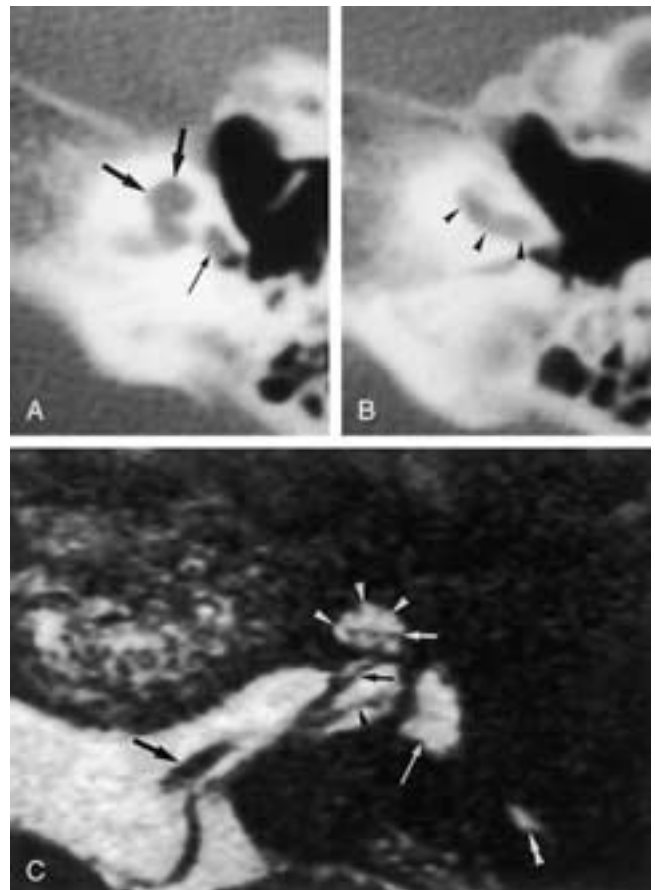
Mondini malformation and hypoplasia of the cochlear branch of the VCN in a patient with the branchio-oto-renal syndrome. A and B, Axial CT image through the apical and second turns of the left cochlea (A) and through the basal turn (B). The apical and second turns of the cochlea cannot be separated from one another on CT (*large black arrows*). The basal turn, however, has a normal shape and appearance (*black arrowheads*). Normal vestibule (*long black arrow*). C, Axial 0.7 mm thick T2-weighted gradient-echo image through the left IAC. An incomplete and obliquely orientated septum (*small white arrow*) is seen between the apical and second turns of the cochlea (*white arrowheads*). The cochlear branch of the VCN (*small black arrow*) is much smaller in diameter than the facial nerve (*large black arrow*). Normally these nerves have a more equal size. Normal vestibule (*long white arrow*), posterior semicircular duct (*double white arrowhead*), and inferior vestibular branch of the eighth nerve (*black arrowhead*).
